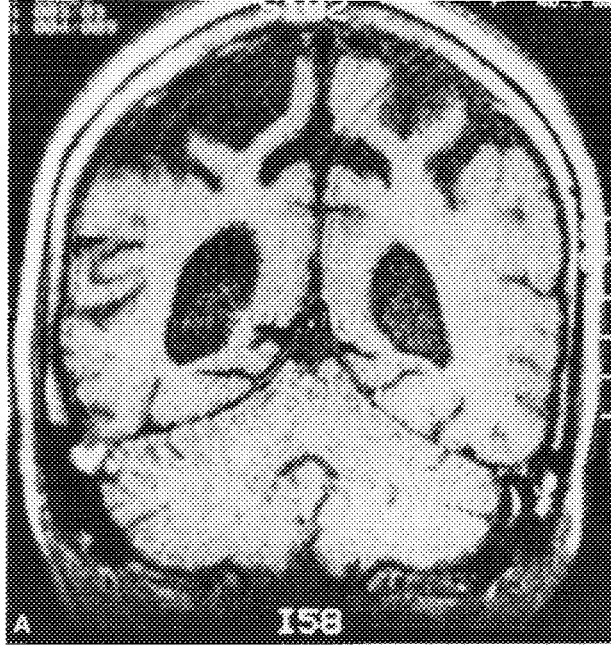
(A,B,C) Coronal MRI scan demonstrating asymmetrical bilateral atrophy of the posterior-superior parietal regions.
